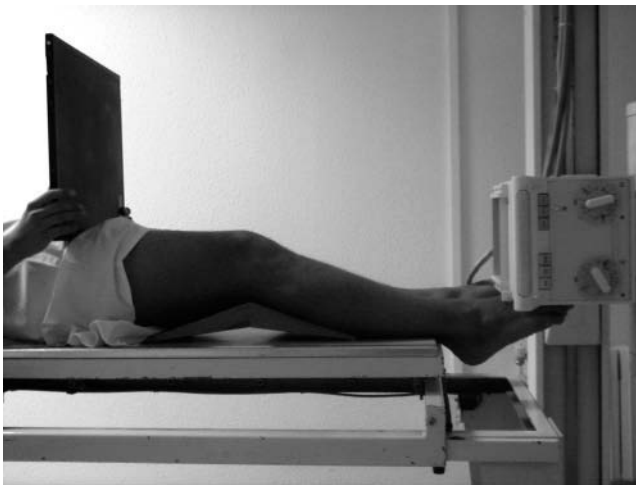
Axial patellar radiograph with a 30 degree wedge.
